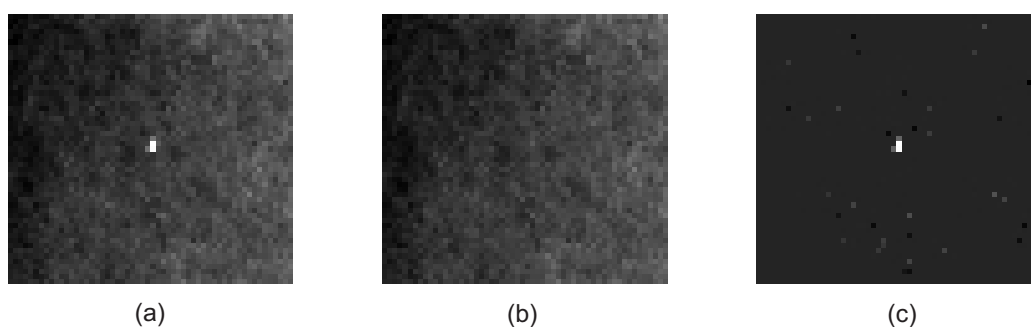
Multiple-pixel impulse noise removal using the MAD-based outlier filter. (a) original radiograph with 5 pixels corrupted by impulse noise (b) denoised image; (c) method noise.
